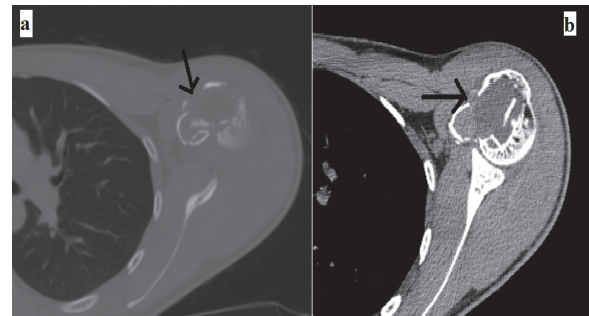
Pathologic fracture left humerus sagittal CT images taken before surgery(2a), fracture fragments and loculated areas are seen in cross-section (arrows mark the parts)(2b).
